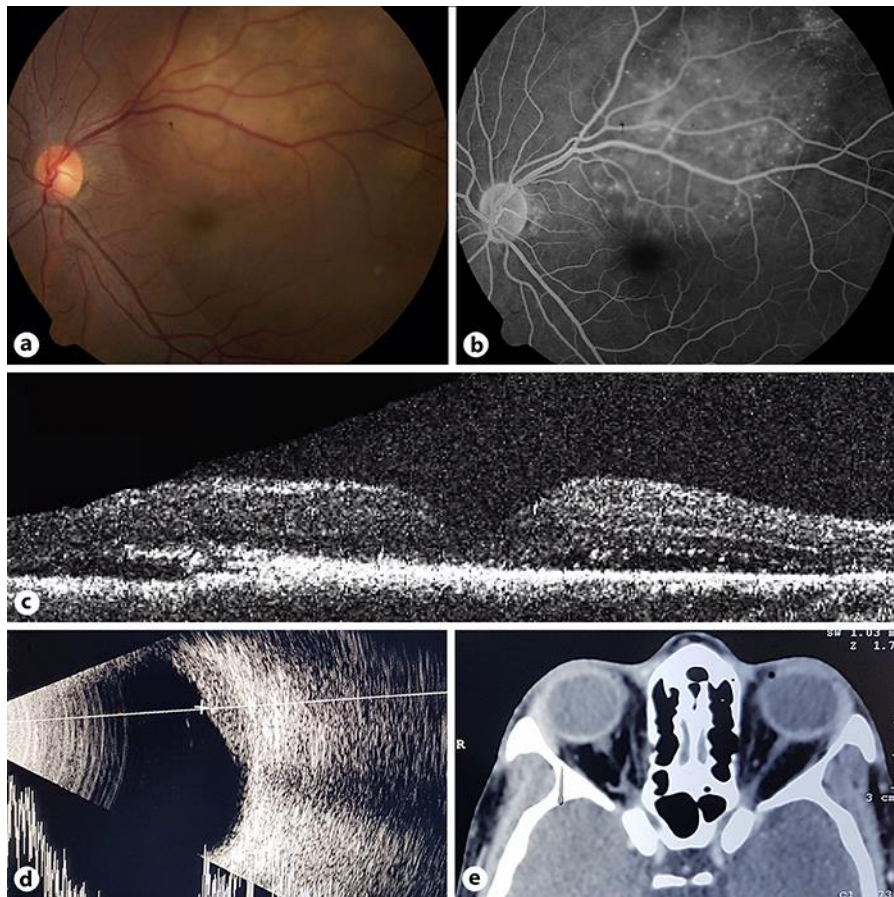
a Clinical picture of the left eye fundus. b Fluorescein angiography of the left eye. c Temporal domain optical coherence tomography. d Ultrasonography mode AB of the left eye. e Simple tomography of the orbit and axial projection of the annexes.
